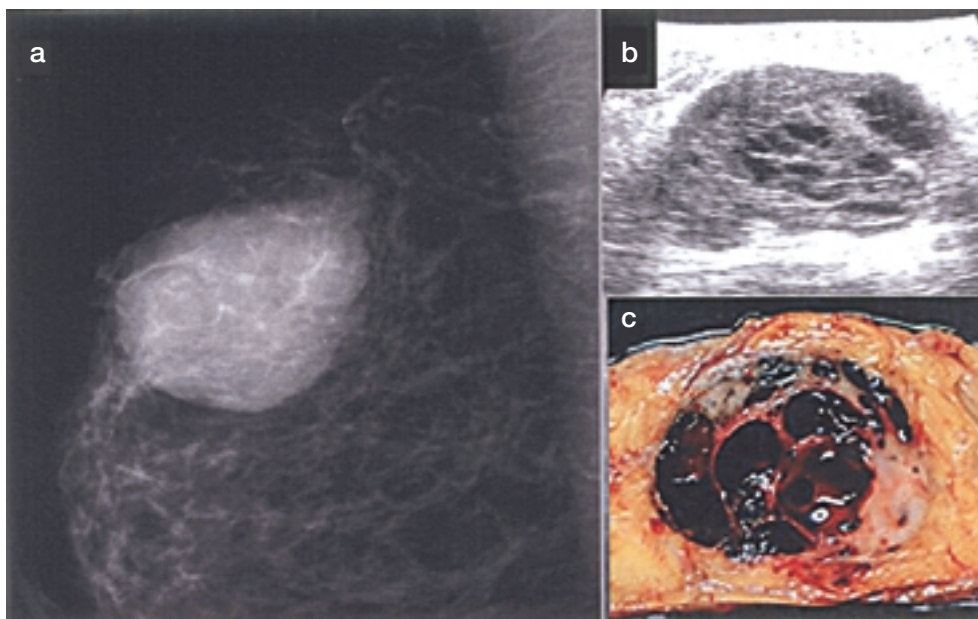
a) Mammography of the right breast demonstrates a well-circumscribed, lobulated mass. b) Ultrasonography of the right breast showing a restricted mass with heterogeneous high echogenicity. c) Macroscopic finding of the cut section of the tumor. Well-circumscribed, non-encapsulated tumor with cystic changes and hemorrhagic necrosis are seen.
